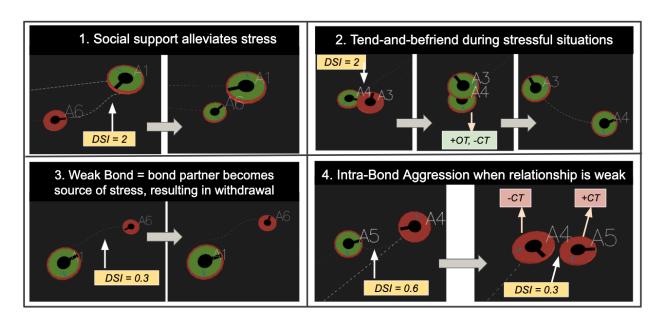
Screenshots of four different emergent social scenarios, which we discuss in detail in this section. Green agents indicate agents who are not stressed, red agents indicates agents who are stressed. Agents are facing in the direction of the black line. Scenario 1: Agent A6 is stressed, and seeing a bond partner (A1) with a strong affective bond reduces cortisol levels and alleviates A6's stressed state. Scenario 2: When bonds are strong or fixed, A4 approaches its stressed bond partner A3 to *Groom*, increasing A4's oxytocin (OT) and reducing cortisol (CT), alleviating stress. Scenario 3: A weakened affective bond between A1 and A6 results in A1 no longer providing the "social buffering" effect, instead becoming a source of stress resulting in A6 avoiding it. Scenario 4: When affective bonds are weak, bond partners are targeted to perform *Aggression* on, further reducing the bond strength (DSI) between them, and increasing stress levels (CT) on recipient.
